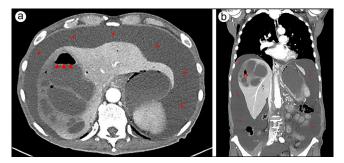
(a) Axial and (b) coronal CT scans of the abdomen at the time of admission showing multiple liver abscesses with air-fluid levels (arrowheads) essentially replacing most of the right hepatic lobe. The largest abscess measured $8 \times 6 \times 10$ cm. Large volume ascites (asterisks) are also noted.
